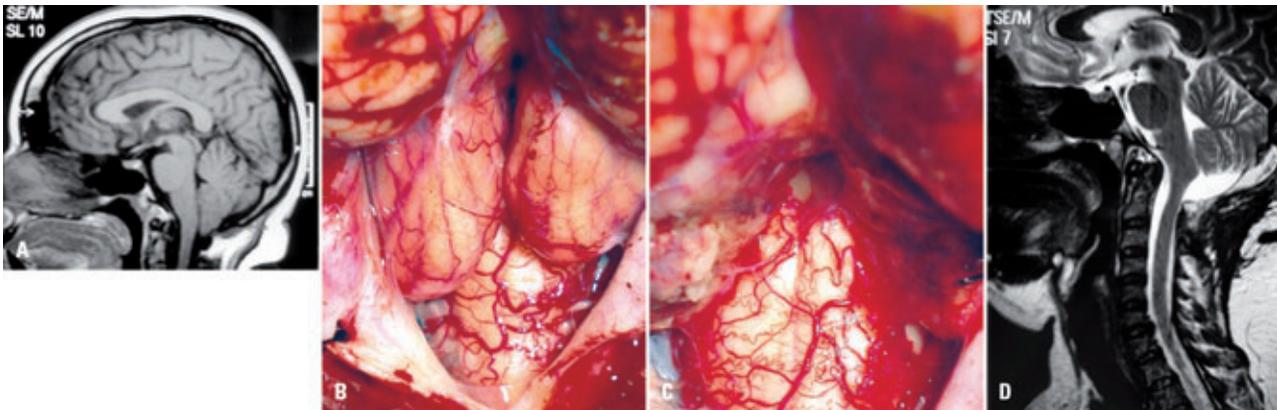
[A] Preoperative MRI demonstrating CM at the level of C1. [B] Extensive herniation of the cerebellar tonsils with the patient in sitting position. [C] Tonsillectomy and large opening of the fourth ventricle. [D] Postoperative MRI showing creation of a large artificial cisterna magna.
